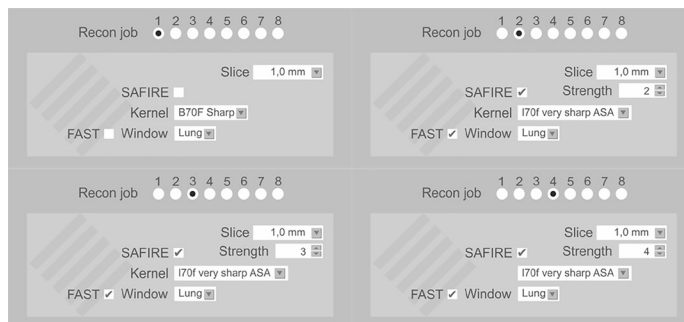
Parameter Setting in FBP B70F Sharp and SAFIRE I70f (level 2,3,4). The data were, then, collected and reconstructed by using kernel filter B70f sharp lung window and SAFIRE soft tissue standard I70f sharp level 2,3 and 4. Various studies using FBP B70F Sharp as a standard filter in Chest HRCT reconstruction because it can increase spatial resolution which is an important aspect in Chest HRCT.
